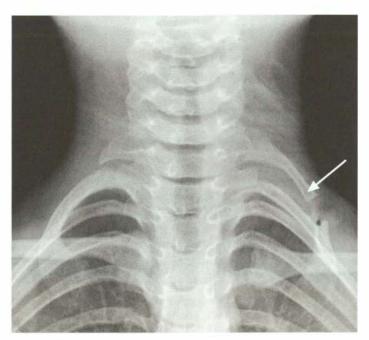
X-ray of the neck showing cervical rib
